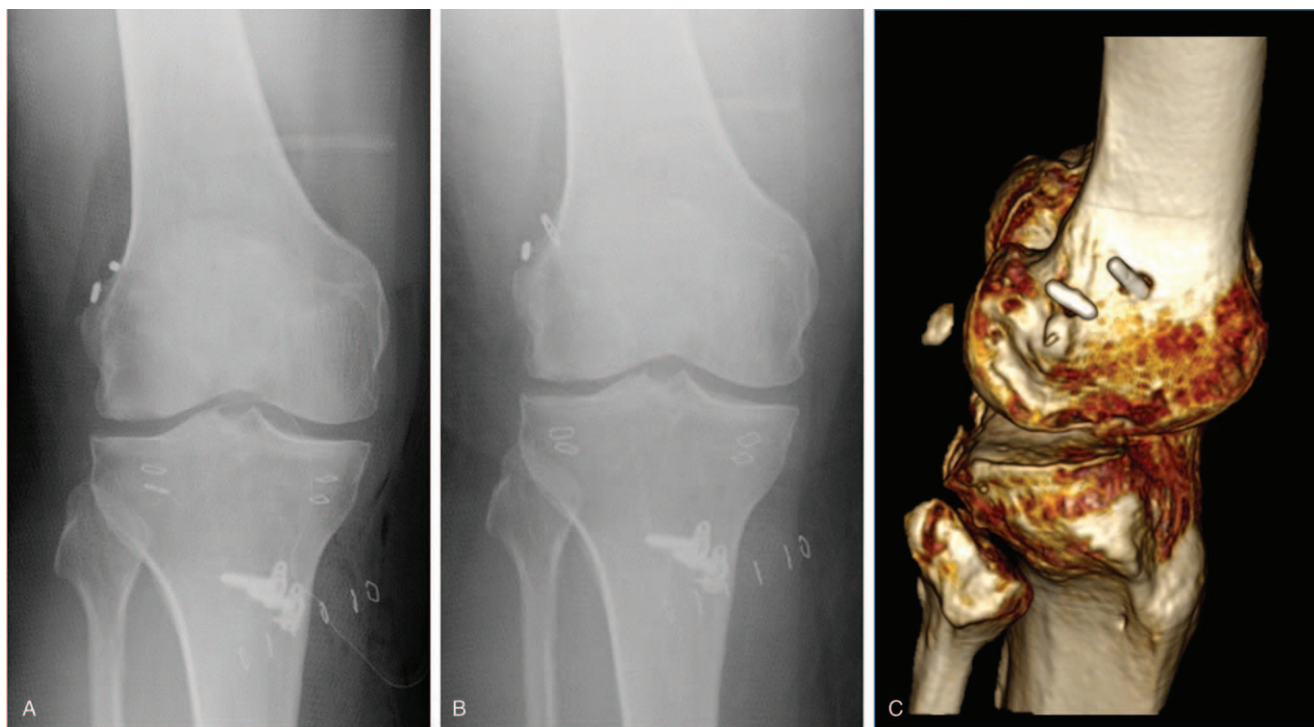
A case of intratunnel migration of cortical button. (A) was immediate postoperative anteroposterior radiograph. Secure fixation of the cortical button on the lateral femoral cortex was reconfirmed in the postoperative radiographs. (B) Five days postoperative anteroposterior radiograph. The cortical button of the anteromedial graft appears to have migrated within the bone (compared with the immediate postoperative radiographs). (C). One-week postoperative Computed tomography. Three-dimensional Computed tomography images show migration of the anteromedial cortical button.
